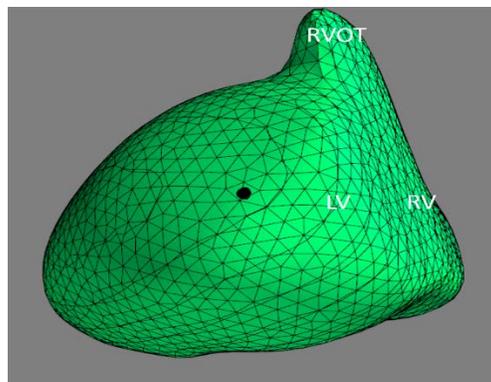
Epicardial polygonal CT model imported into custom written software with Python. Black dot – central marker of late activation zone.
